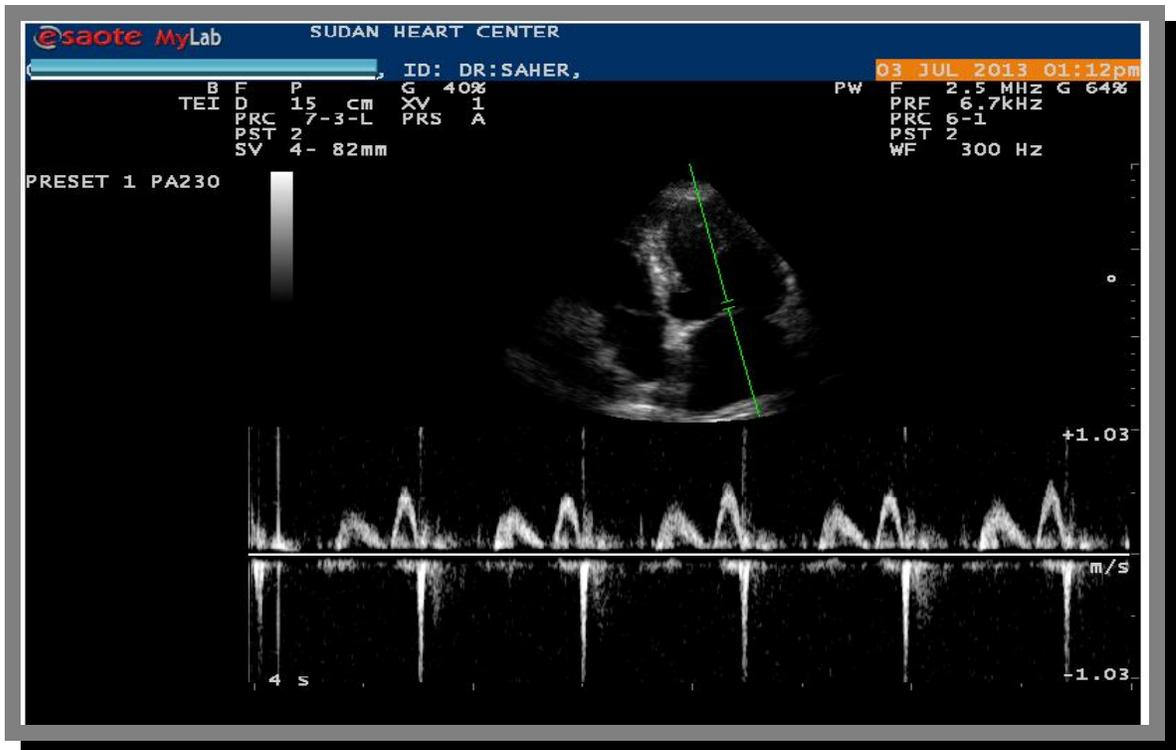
Pulse wave doppler assesses the mitral valve.
